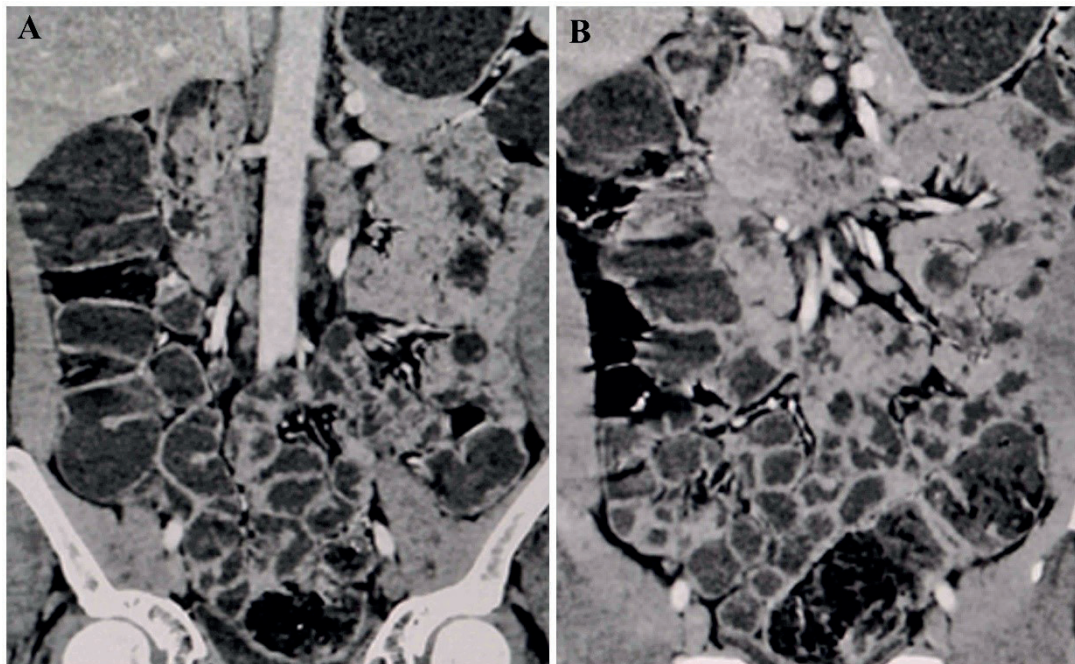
CT enterography. Coronal images showing A: adequate luminal distention & uniform wall enhancement of normal jejunal and ileal loops, B: prominent mucosal pattern of normal jejunal loops.
